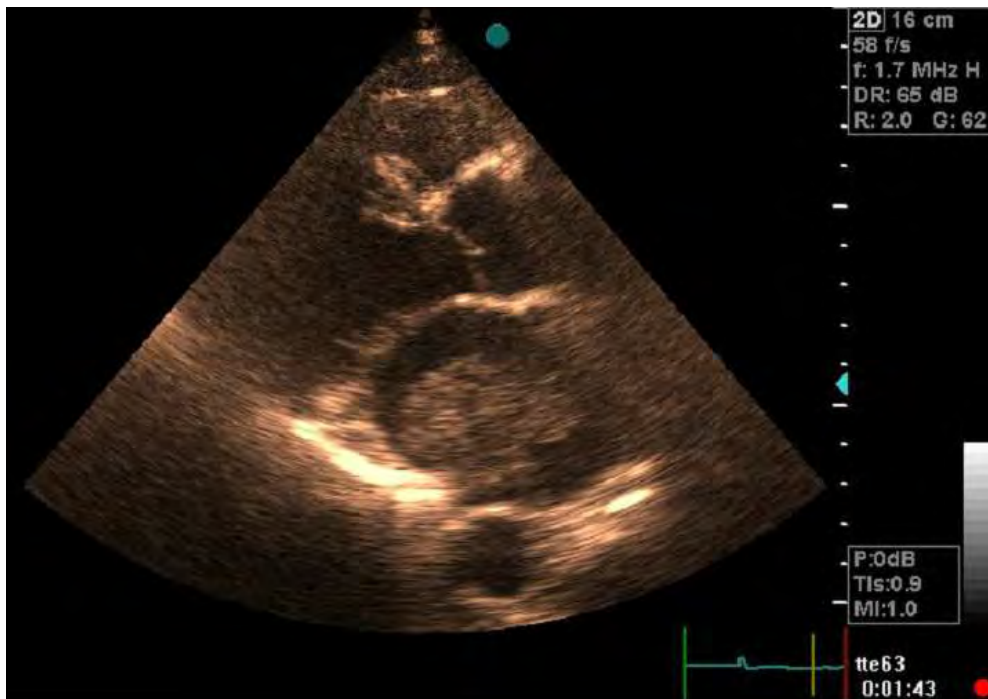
Parasternal long axis view. A 38 year old man with history of dyspnea. Echocardiography revealed left atrial mass. He underwent cardiac surgery and pathology showed myxoma.
